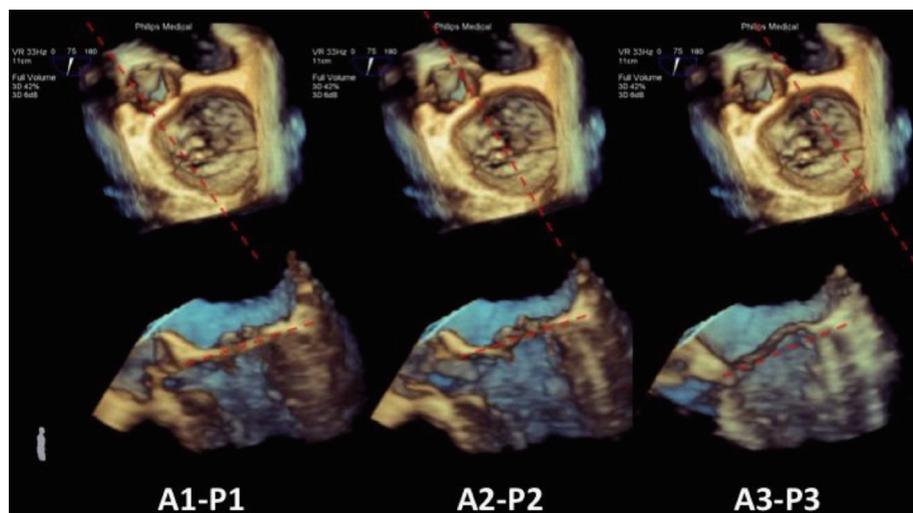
Three-dimensional trans-esophageal echocardiography facilitates evaluation of mitral valve leaflets. Cross-plane of the surgical view makes easier to measure the prolapse height of every segments. At the bottom in the figure, sagittal view of the valve at different levels. The annular plane is highlighted by the dotted line.
